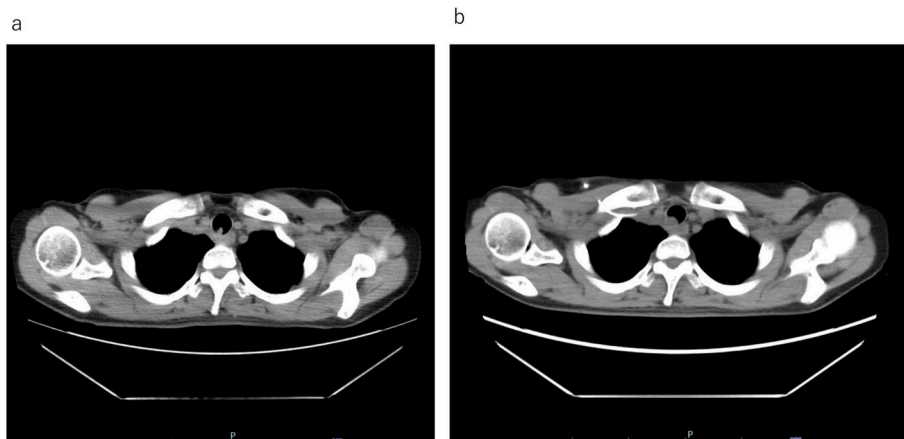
Computed tomography (CT). a. Chest CT image obtained after the initial diagnosis of endobronchial metastasis. CT revealed the presence of a tumor in the posterior wall of the upper portion of the trachea. b. Chest CT image obtained 3 months after the initial diagnosis of endobronchial metastasis. CT revealed that the size of the tumor had increased.
